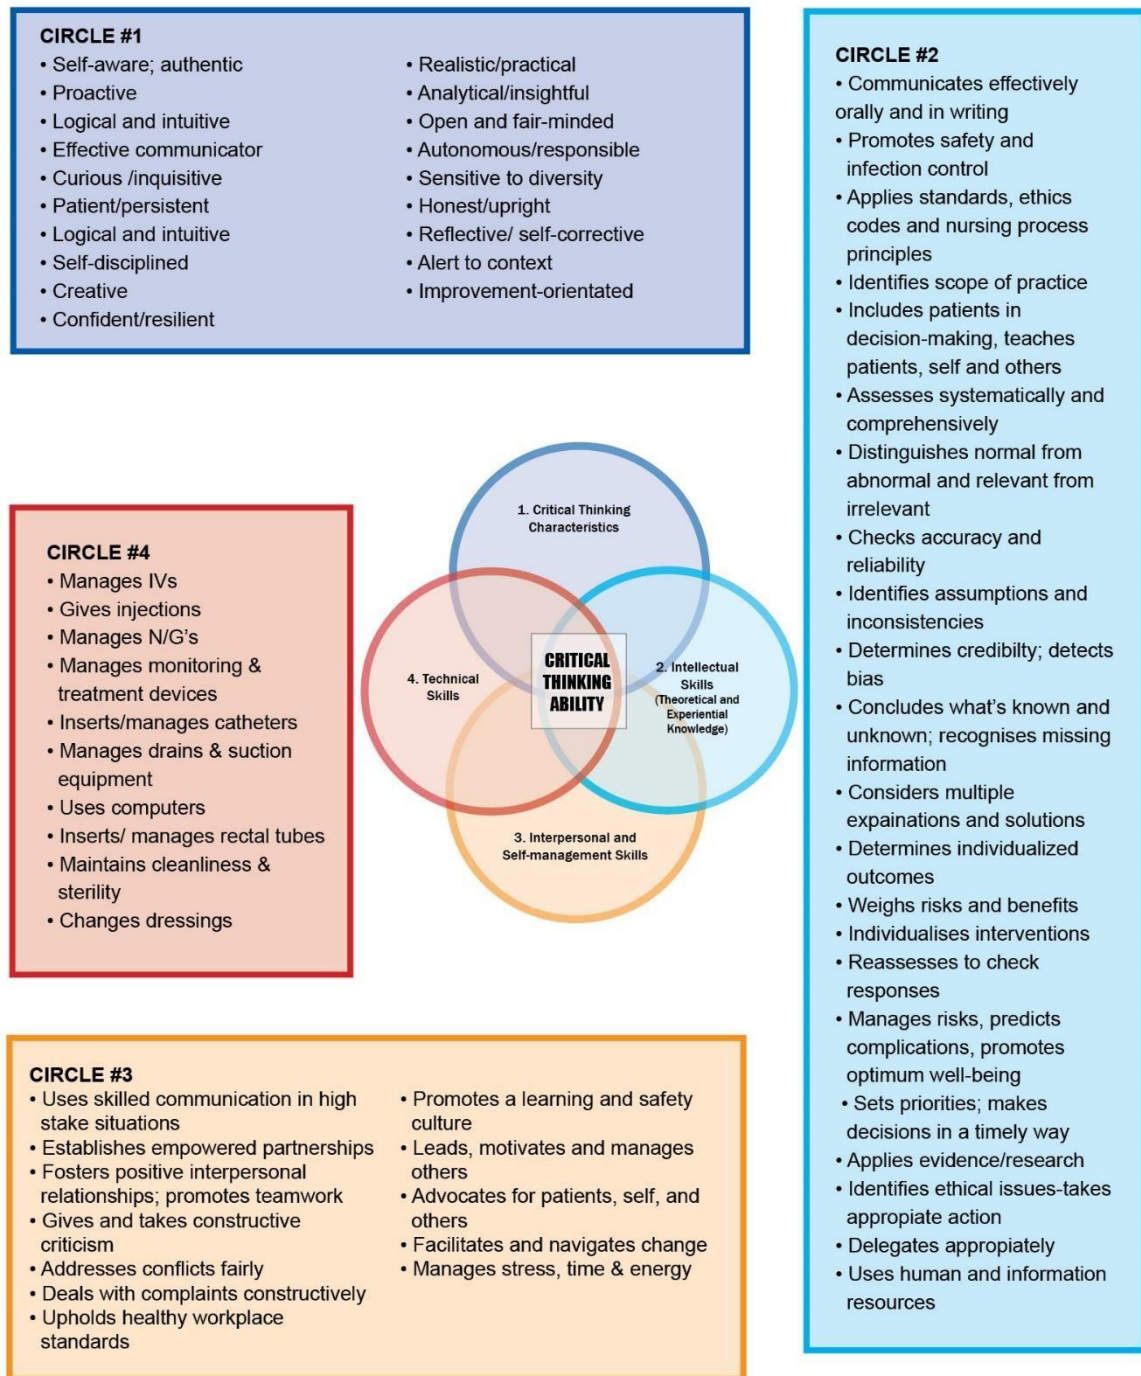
4-Circle CT model®
